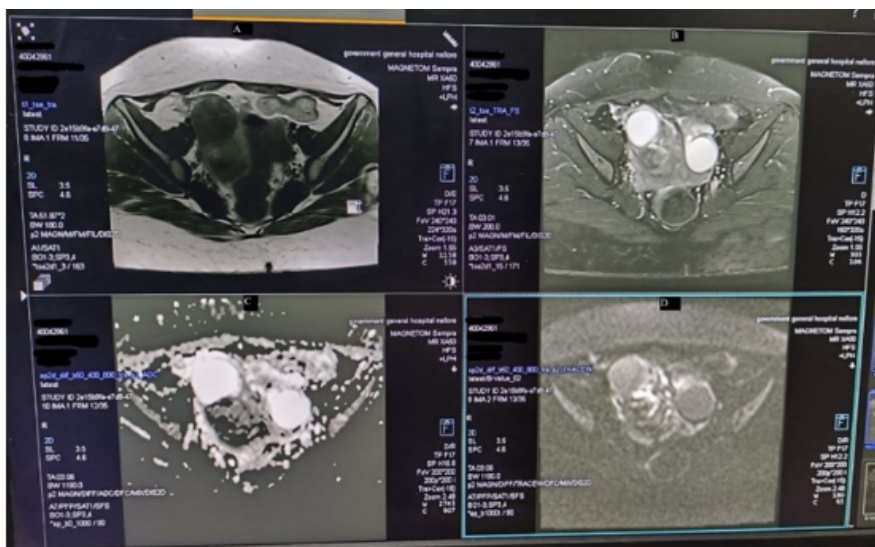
A. Axial T1 weighted image of MRI pelvis showing hypointense lesions in bilateral adnexal regions B. On T2 weighted image lesions are hyperintense. C. ADC image showing facilitated diffusion. D. DWI image with no Restricted diffusion
